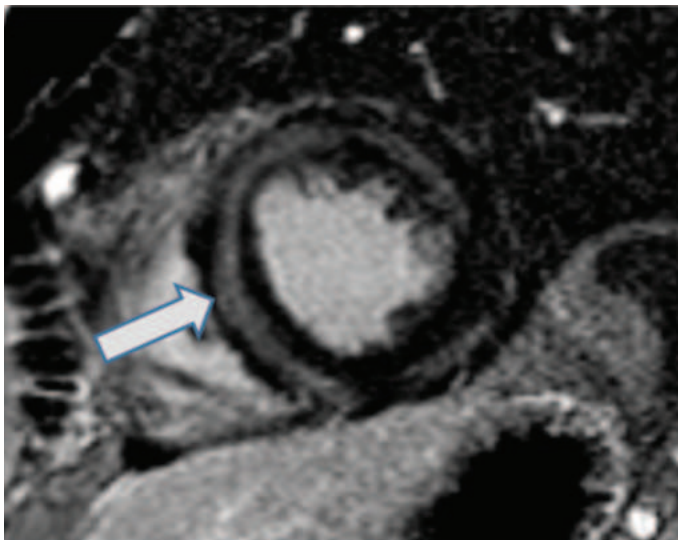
Magnetic resonance image of myocarditis showing the typical mid-wall location (arrow) for late gadolinium enhancement from cardiac inflammation and scarring. (Image courtesy of Ron Blankstein, MD, and Marcelo Di Carli, MD, Division of Nuclear Medicine, Brigham and Women's Hospital, Boston.)
